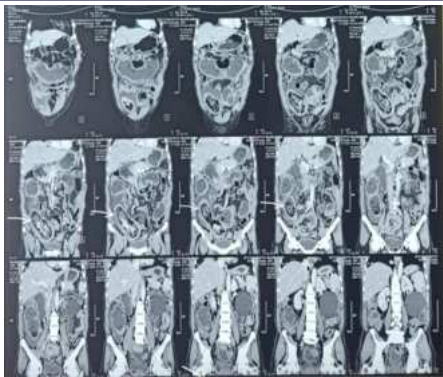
Coronal section of a contrast-enhanced CT (CECT) of the abdomen revealing a mixed-density lesion within the lumen of the terminal ileum, accompanied by a large cyst located at the superior pole of the left kidney, with visible bowel distension. (The white arrow indicates the lesion).
